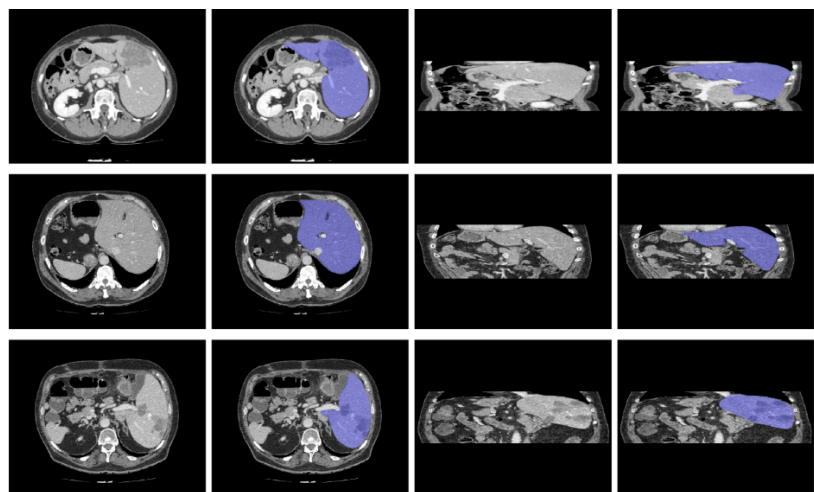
Examples of original computed tomography/magnetic resonance imaging images
